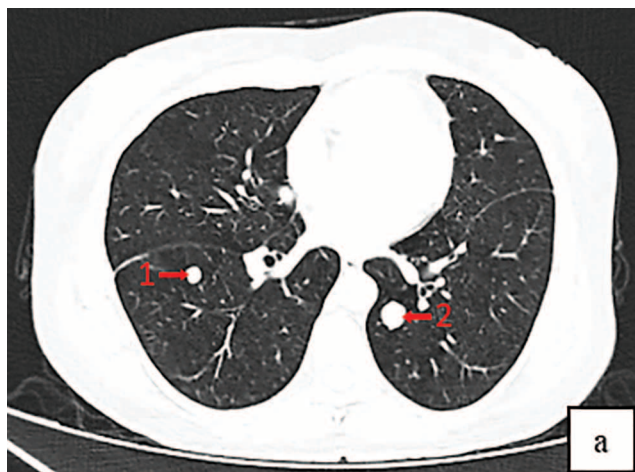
CT scan of the chest (a, b)
